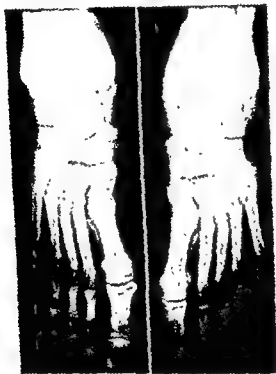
Calcification of interdigital arteries of feet, visualized by soft tissue x-ray technic.
